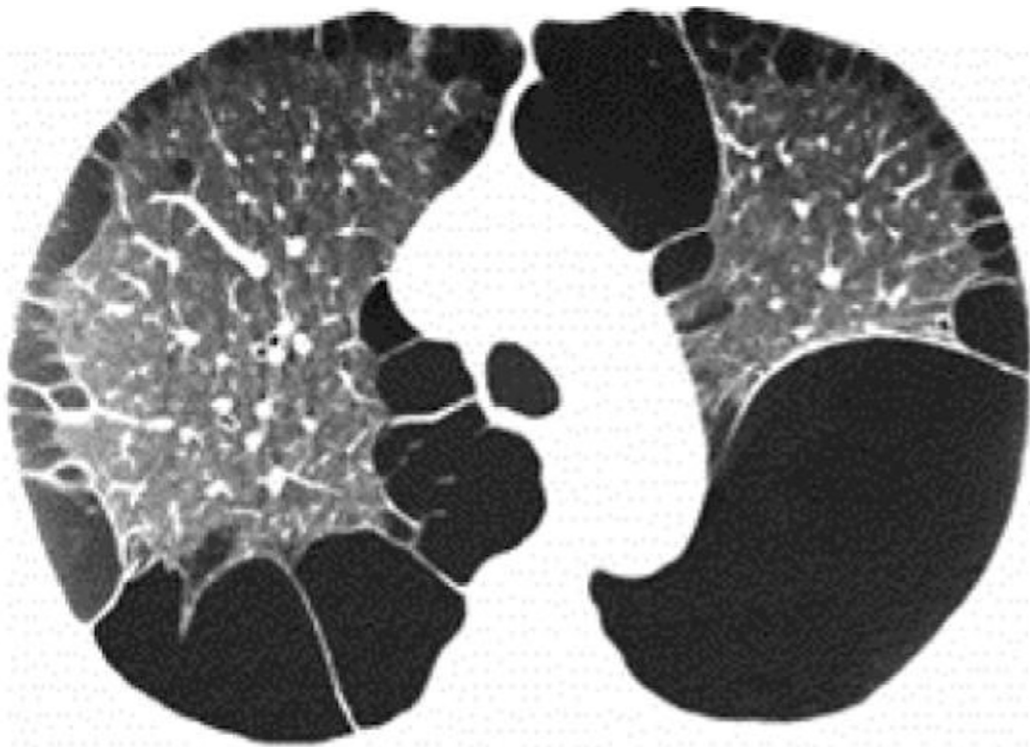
An axial CT scan with lung window settings revealing severe bullous emphysema and bilateral paraseptal emphysema.
